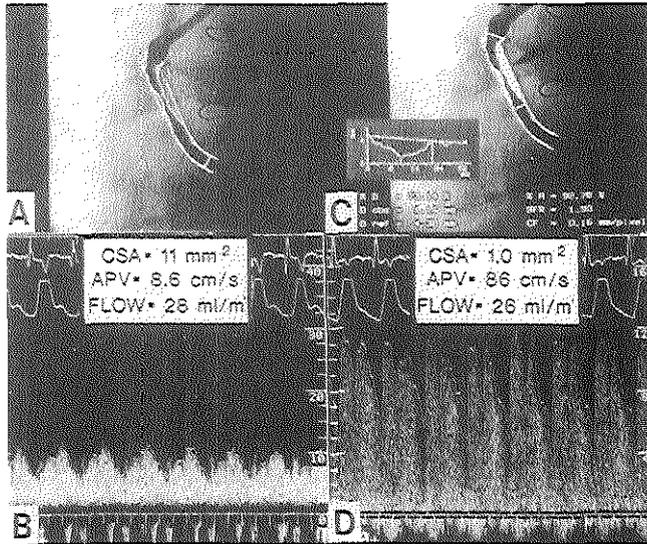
Upper panels: magnified digital angiogram of the middle segment of a right coronary artery with a severe coronary stenosis. A, measurement at the site of the Doppler sample volume, distal to the stenosis; C, minimal luminal diameter (Philips DCI-ACA analysis package). Lower panels: flow velocity recordings distal to the stenosis (B) and in the stenosis (D). Note the large velocity increase (maximal velocity of 230 cm/sec). APV = average peak velocity; CSA = cross-sectional area (mm^2). Note that the scale is changed from 0–90 cm/sec in B to 0–320 cm/sec in D for jet analysis.
